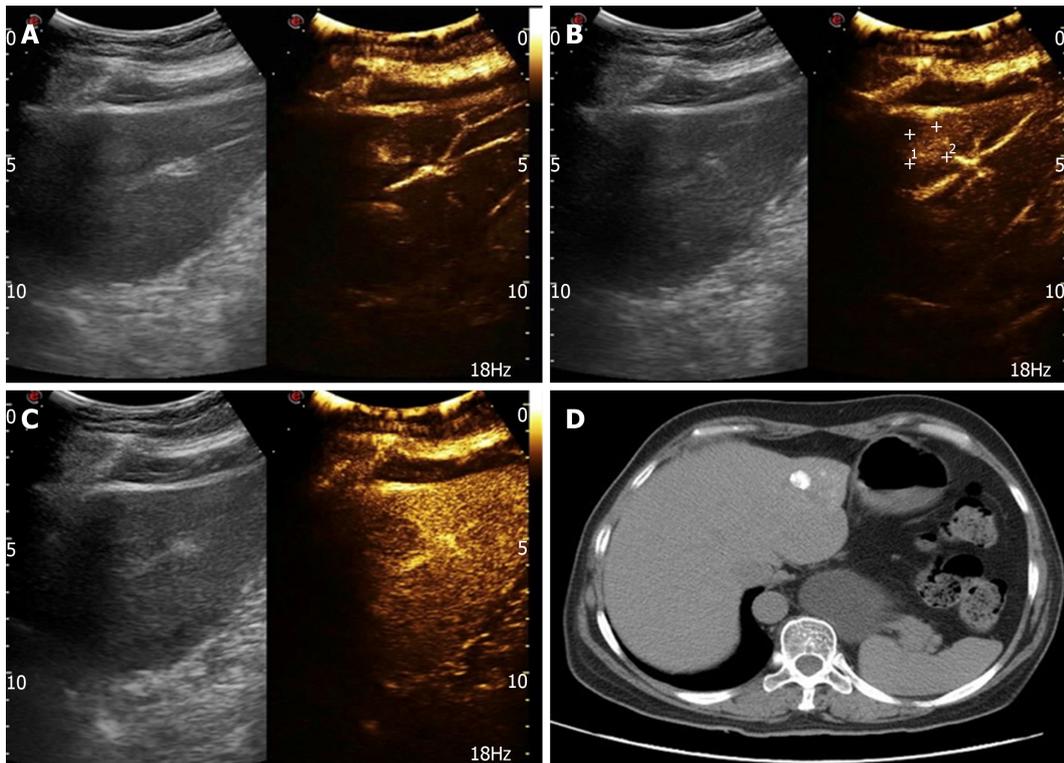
Ultrasound and computed tomography images of liver metastases. A: Fast-in image of a metastatic tumor in liver; B: Homogeneous and highly enhanced images of metastatic tumors in liver; C: Fast-out image of a metastatic tumor in liver; D: Computed tomography image of hepatic arterial infusion of lipiodol after transcatheter arterial chemoembolization.
